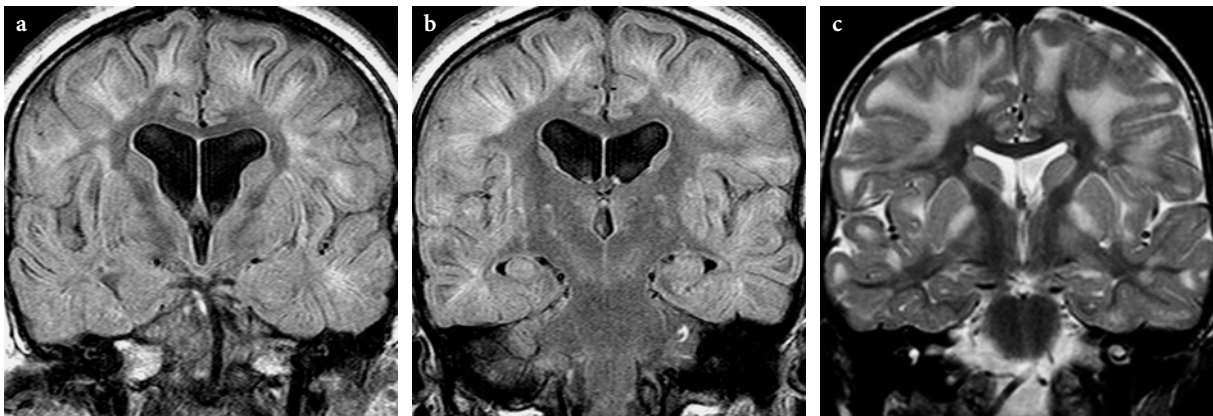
a, b Coronal FLAIR images in 21-year-old female patient with L-2-hydroxyglutaric aciduria. a The subcortical U-fibers exhibit a markedly hypointense appearance, almost identical to CSF signal intensity. This suggests complete demyelination. b The centripetal gradient of the demyelinating process is well demonstrated. Below the hypointense subcortical U fibers, a hyperintense zone is seen, which probably corresponds to partial demyelination. The deep white matter and diencephalic and brainstem structures are normal. c Coronal T2-weighted image in a 4-year-old girl with L-2-hydroxyglutaric aciduria (courtesy of Dr. P. Tortori-Donati, Genoa, Italy). White matter changes involve the subcortical white matter and spare the central white matter and corticospinal tracts. The globi pallidi and external capsules are also involved
